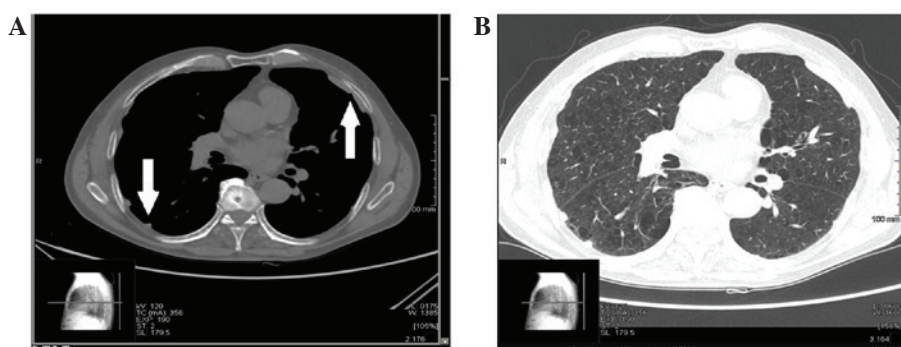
Non-enhanced high-resolution computed tomography images. (A) View of the mediastinum, (B) view of the parenchyma. Unilateral calcified pleural plaques ~1 cm in thickness at the level of the right parietal pleura (arrows) coexist with lung interstitial abnormalities and diffuse lobular septal thickening. The parietal pleura is thickened bilaterally; on the right the pleura is thickened and lobulated in the absence of evident plaque calcification.
